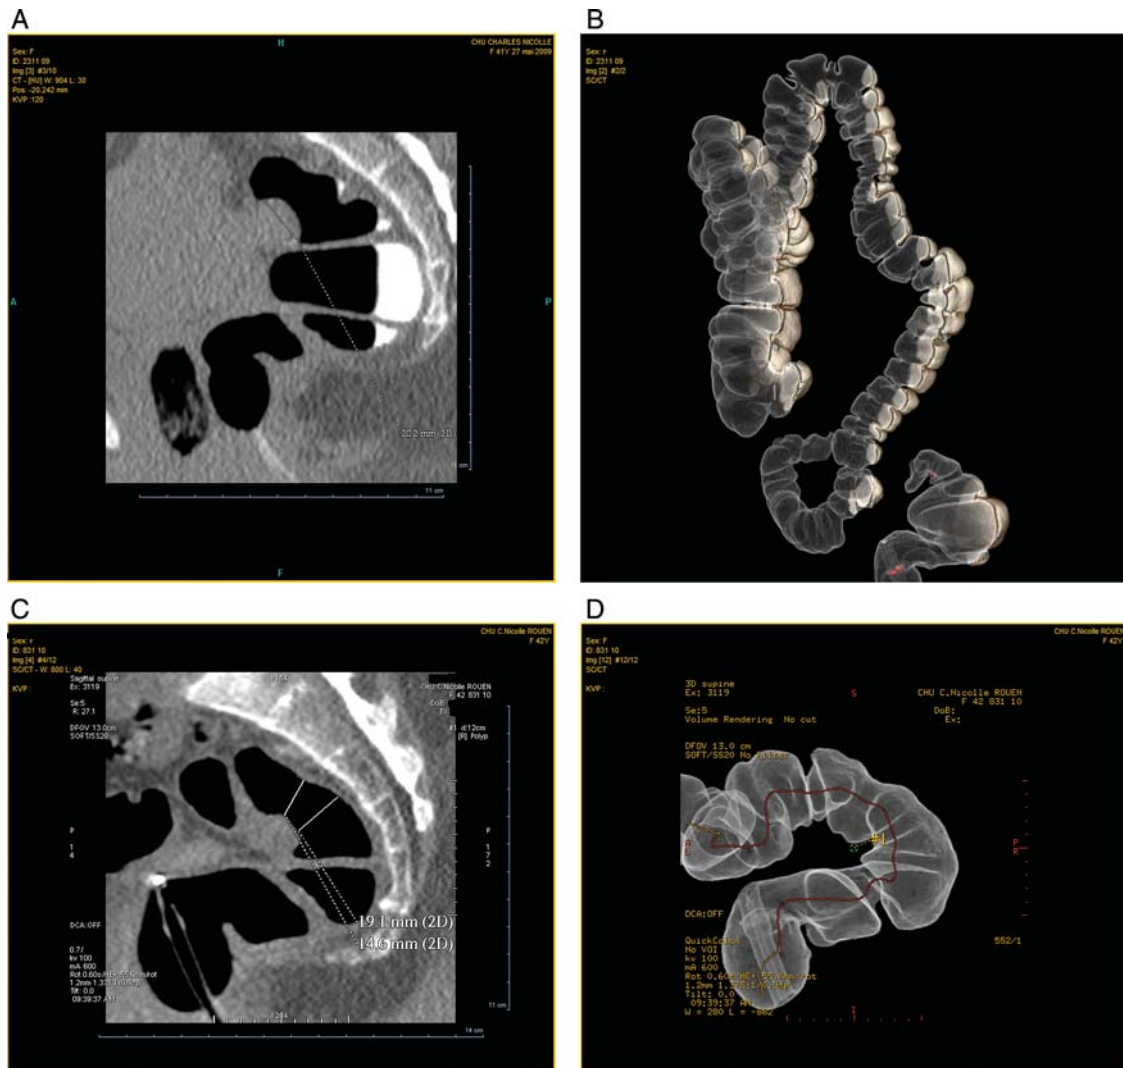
Computed tomography and virtual colonoscopy performed prior to (A and B) and after (C and D) shaving of the rectal nodule carried out in a 45-year-old woman. Post-operative examination reveals a persistent indentation on the anterior rectal wall; however, the increase in rectal diameter allowed complete and definitive relief of digestive symptoms.
